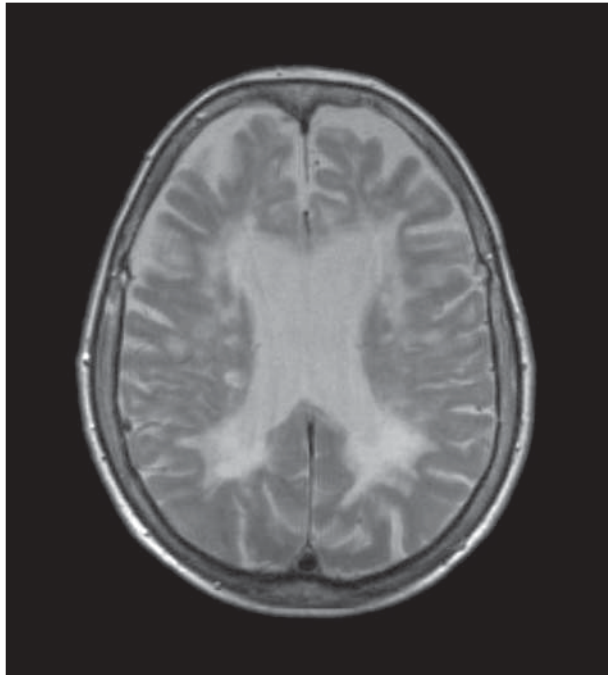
T2-weighted axial brain magnetic resonance image of patient 1 showing confluent and focal high-signal white matter lesions as well as central cortical atrophy consistent with long-lasting progressive multiple sclerosis.
